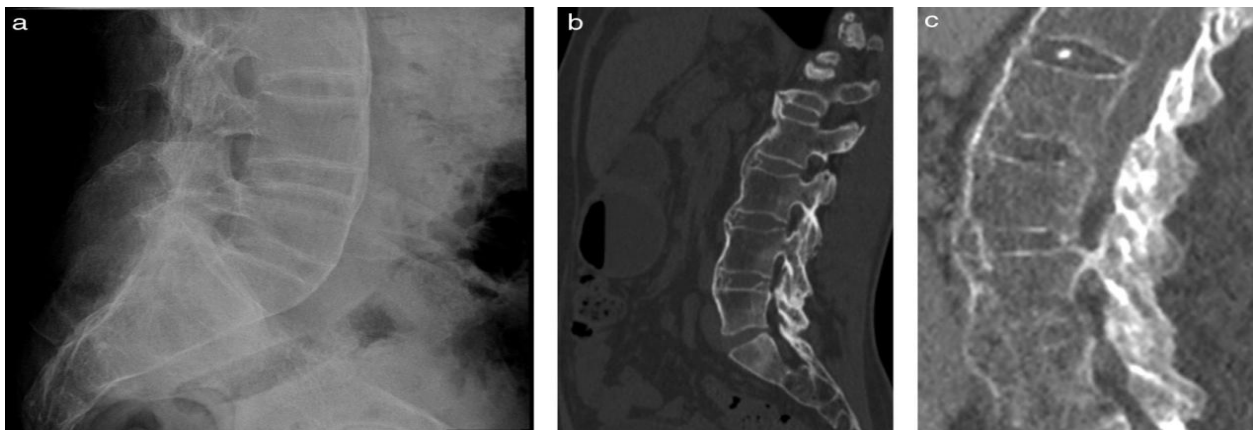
Lateral projection of conventional radiography (a) and selected bone window CT slices (b and c) showing lumbar columns in different patients, with ankylosis of the 3 pillars: anterior, middle and posterior, forming a structure continuous bone in «bamboo cane».
